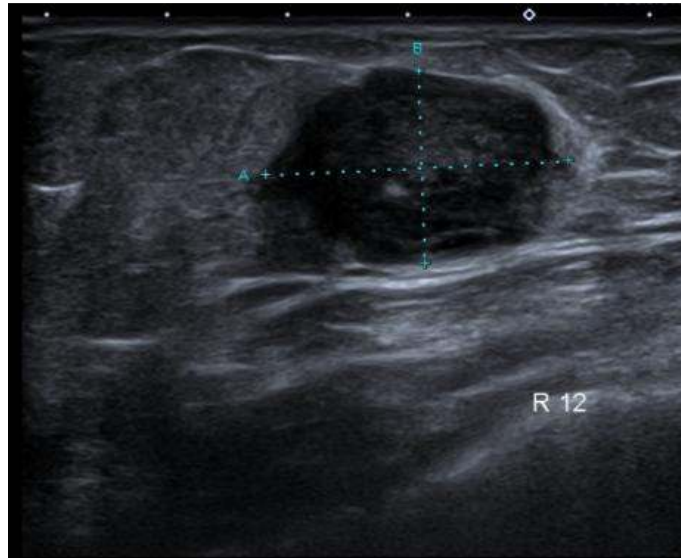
Palpable right breast mass, ultrasonographic appearance of pathologic intramamarian lymph node
